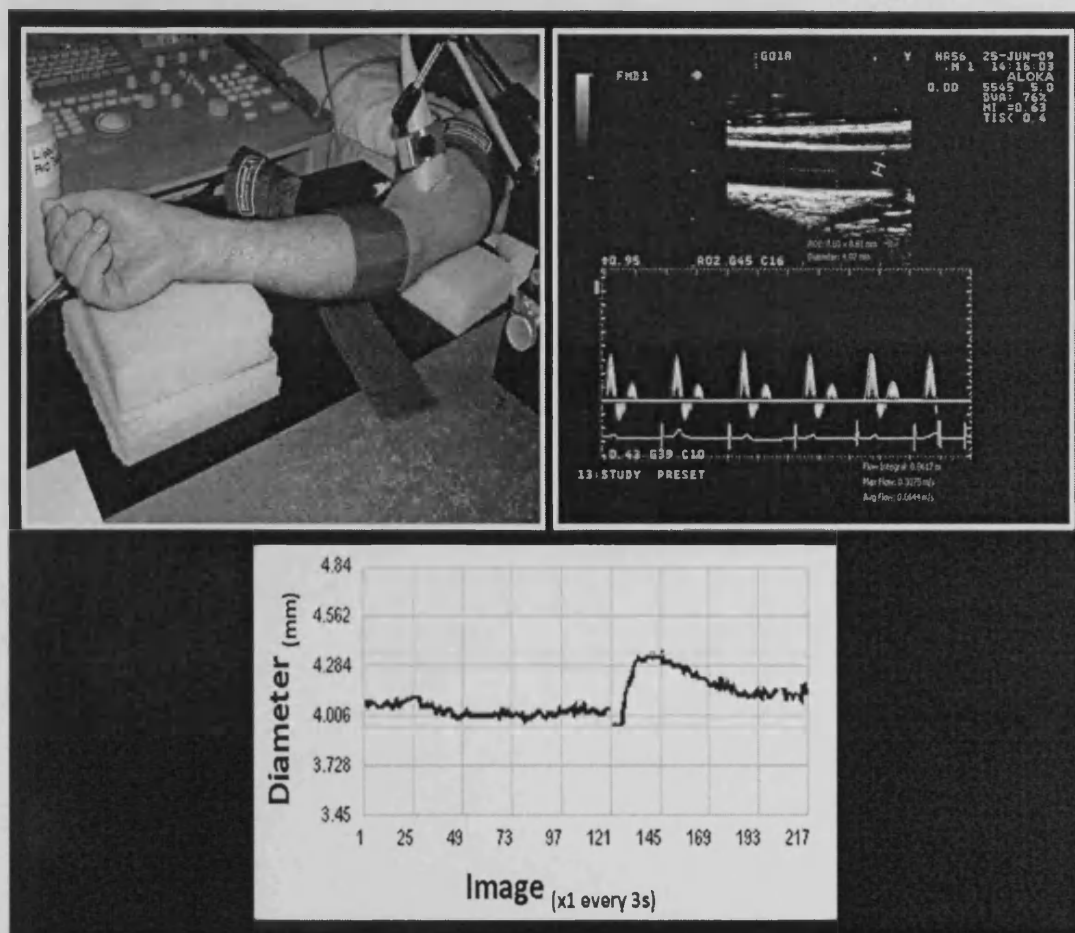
FMD analysis. Clockwise from top left. 1. Picture of the setup for brachial arterial FMD analysis. 2. Ultrasound imaging of the brachial artery (top = longitudinal image of the artery with the region for analysis highlighted, bottom = PWD flow velocity trace from the centre of the artery). 3. Brachial arterial diameter profile during the FMD protocol. Note the steady baseline in the first minute (images 0-20), followed by an increase in arterial diameter after cuff deflation at six minutes (image 120).
